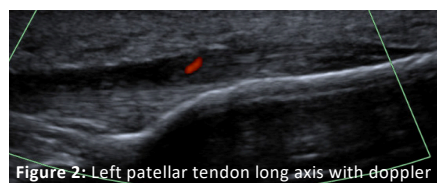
Left patellar tendon long axis with doppler
